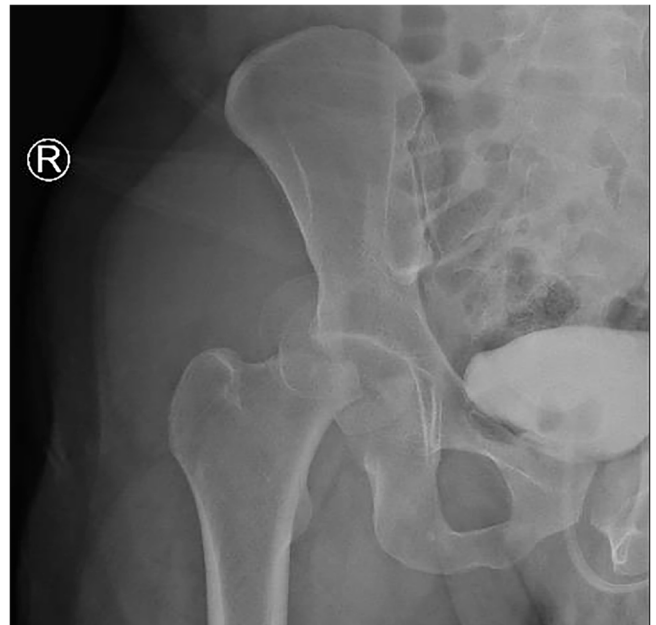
Anteroposterior radiograph of the pelvis after closed reduction attempted. In addition to the hip dislocation and femoral head fracture, a new fracture line through the neck is clear.
